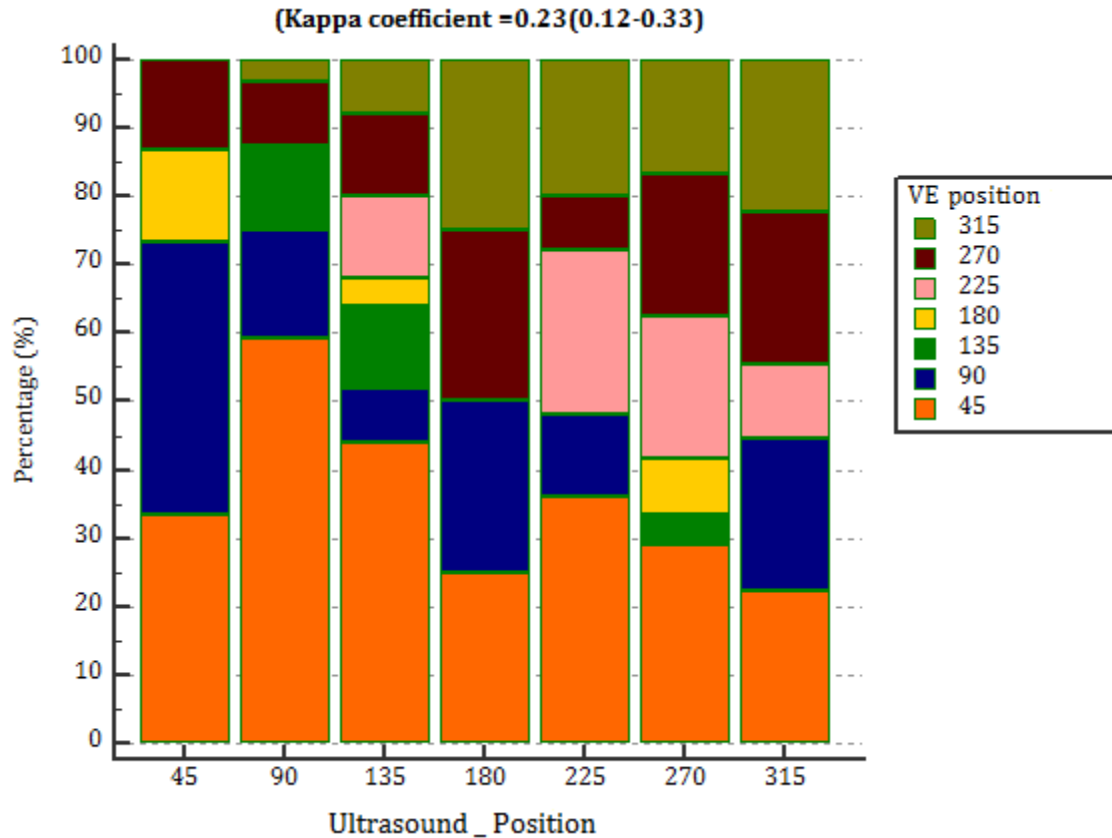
Between-Method Agreement of Ultrasound versus Digital VE on Fetal Head Position
